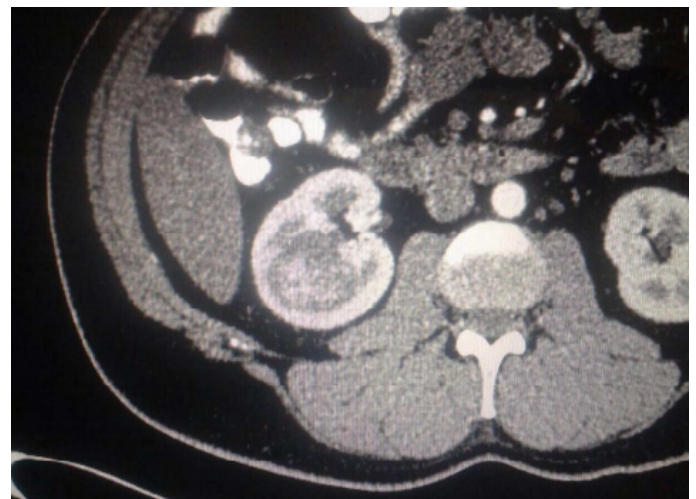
CT scan showing a solid hypercaptating mas in the right renal hilum which is compatible with clear cell carcinoma in direct contact with the renal pelvis and near the artery and vein, making a nephron sparing nephrectomy impossible
